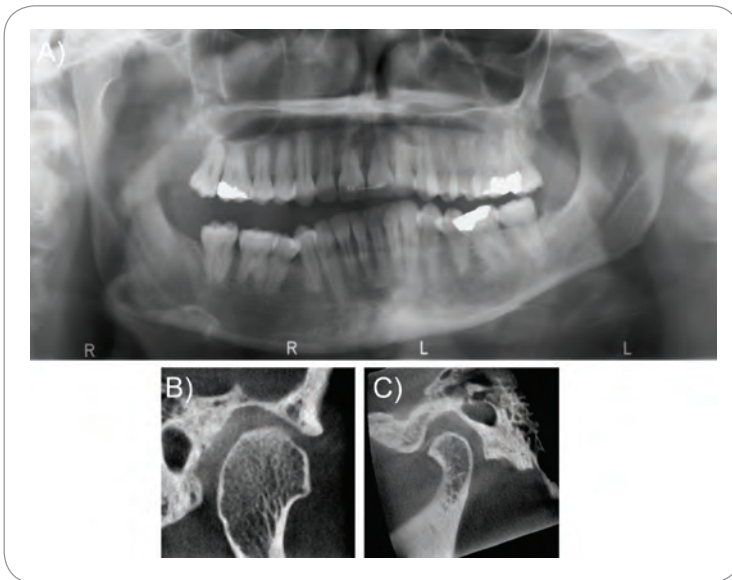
Right condylar hyperplasia seen on panoramic (A) and lateral (B) CBCT sections. Lateral section of the normal left condyle (C) is shown for comparison.
